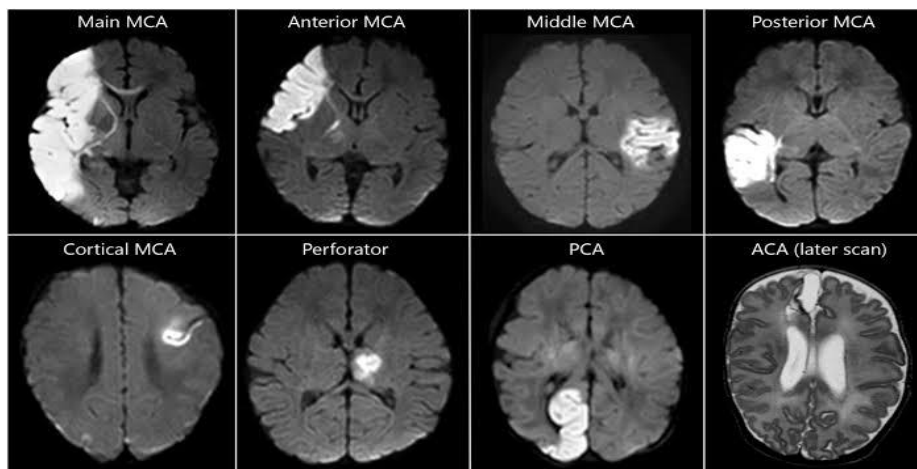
MRI Brain Showing Infarct
